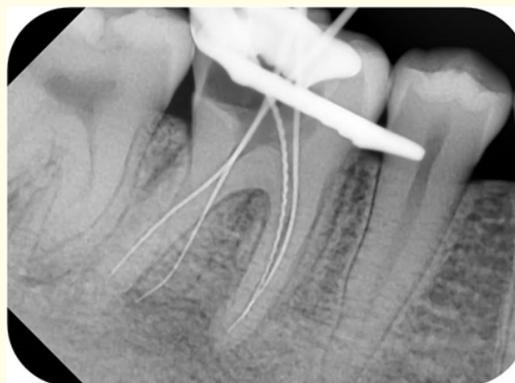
Working length IOPA radiograph of tooth #46 distal angulation.
